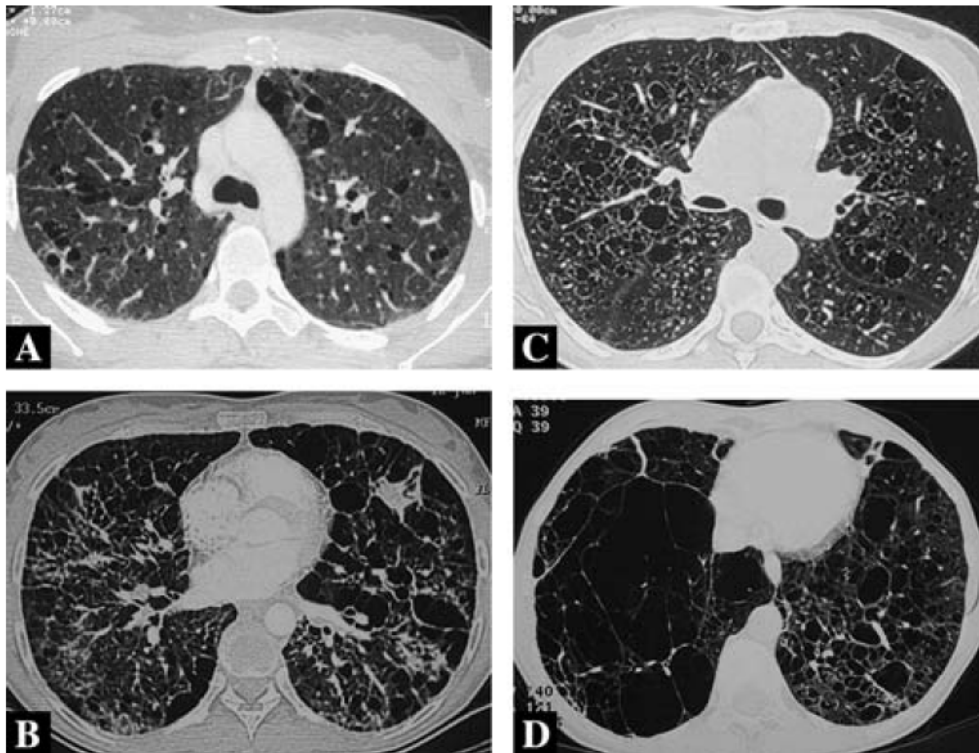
High resolution computed tomography (HRCT) scans of two patients with light chain deposition disease demonstrating progressive cystic abnormality (image reprinted with permission⁶)
